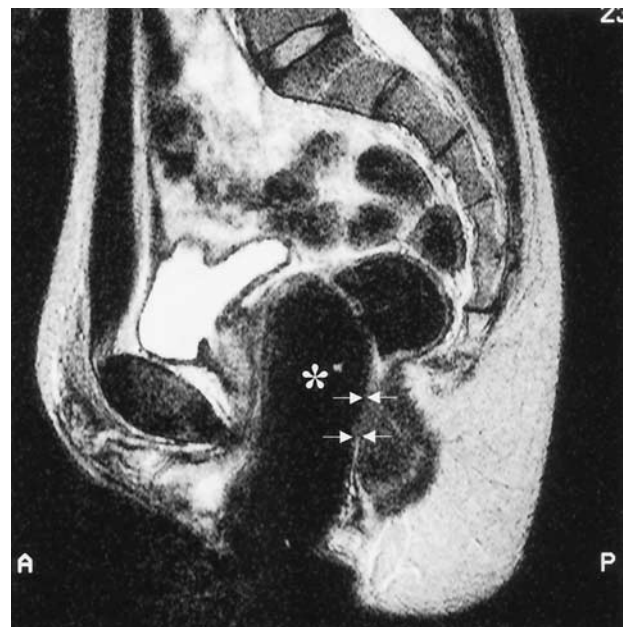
Sagittal turbo spin-echo T2-weighted image shows an inflatable silicon tutor in the neovagina (*). The rectovaginal septum (arrows) is very thin.
